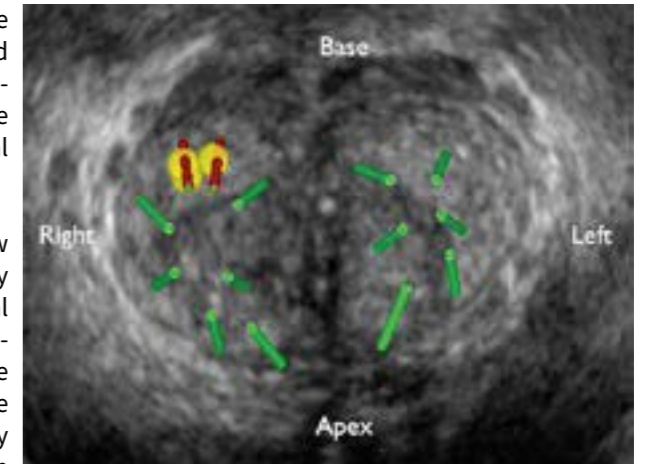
Three-dimensional transrectal US fused image shows the location in the 1a sector of a suspicious focus (yellow; summed PI-RADS score at multiparametric MR imaging, 14) that was targeted by two targeted (red) cores in complement to 12 random (green) systematic cores in a 61-mL prostate.
